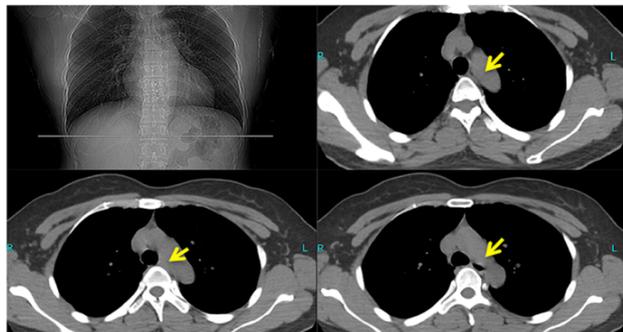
Chest computed tomography (CT) with enhanced contrast revealed a mass localized inside the esophageal wall with slightly low density (arrow) and narrow esophageal lumen.
